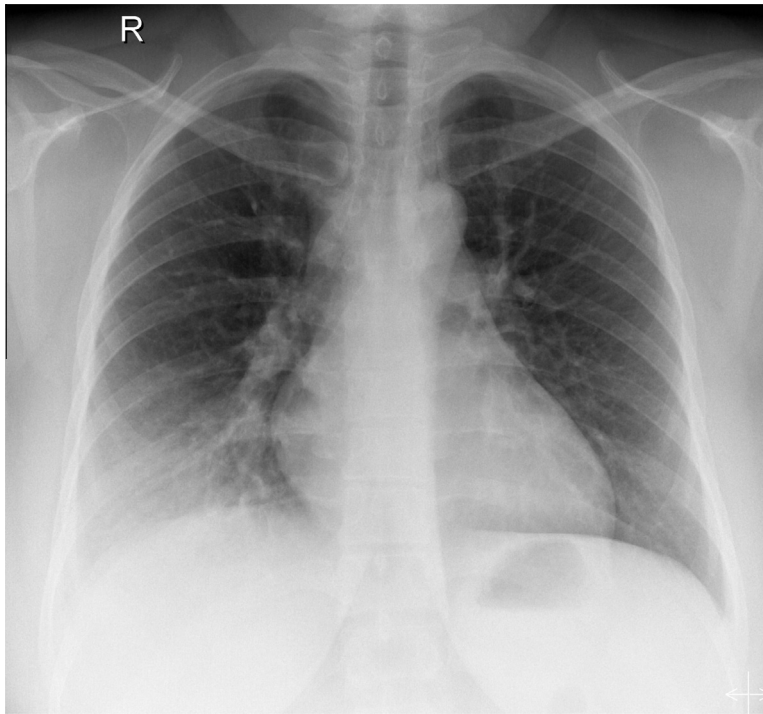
Chest X-ray frontal projection second day after admission showing progression of the right lower zonal opacity.
